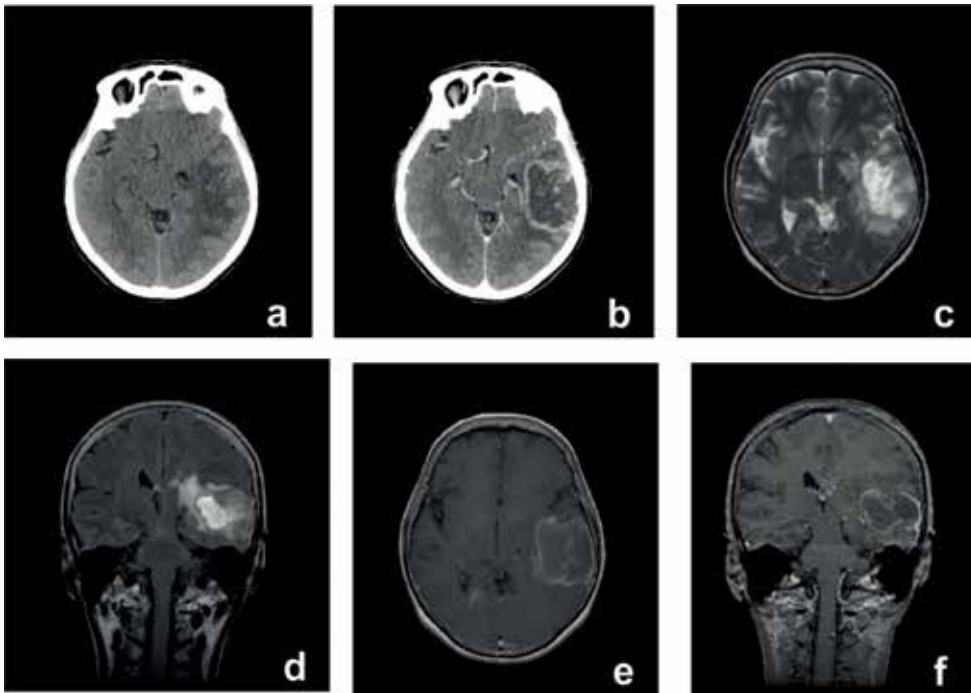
Left temporal glioblastoma. (a) CT scan without contrast; (b) CT scan with contrast; (c) MRI – Axial T2-weighted image; (d) MRI – Coronal FLAIR sequence; (e) MRI – Axial T1-weighted image with contrast; (f) MRI – Coronal T1-weighted image with contrast.
